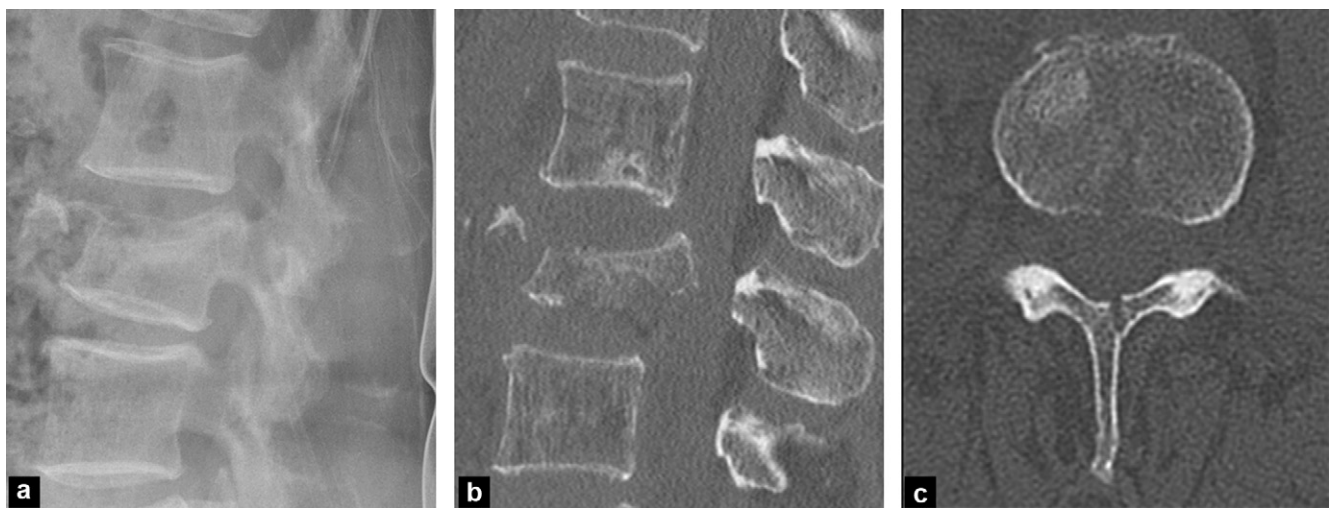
Burst fracture. a: standard X-ray: compression of the upper plateau. Loss of height of the posterior wall with respect to the adjacent levels, without lesion of the posterior arch; b: CT (sagittal reformat); confirmation of damage to the posterior wall; c: vertical spinolaminar split (A3 fracture).
